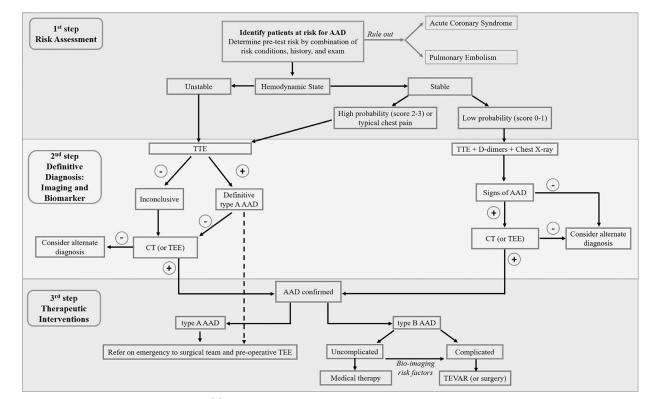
AAS diagnostic algorithm modified from ref.^{1,2} Abbreviations: AAD, acute aortic dissection; AAS, acute aortic syndrome; CT, computed tomography; TEE, transesophageal echocardiography; TEVAR, thoracic endovascular aortic repair; TTE, transthoracic echocardiography.
